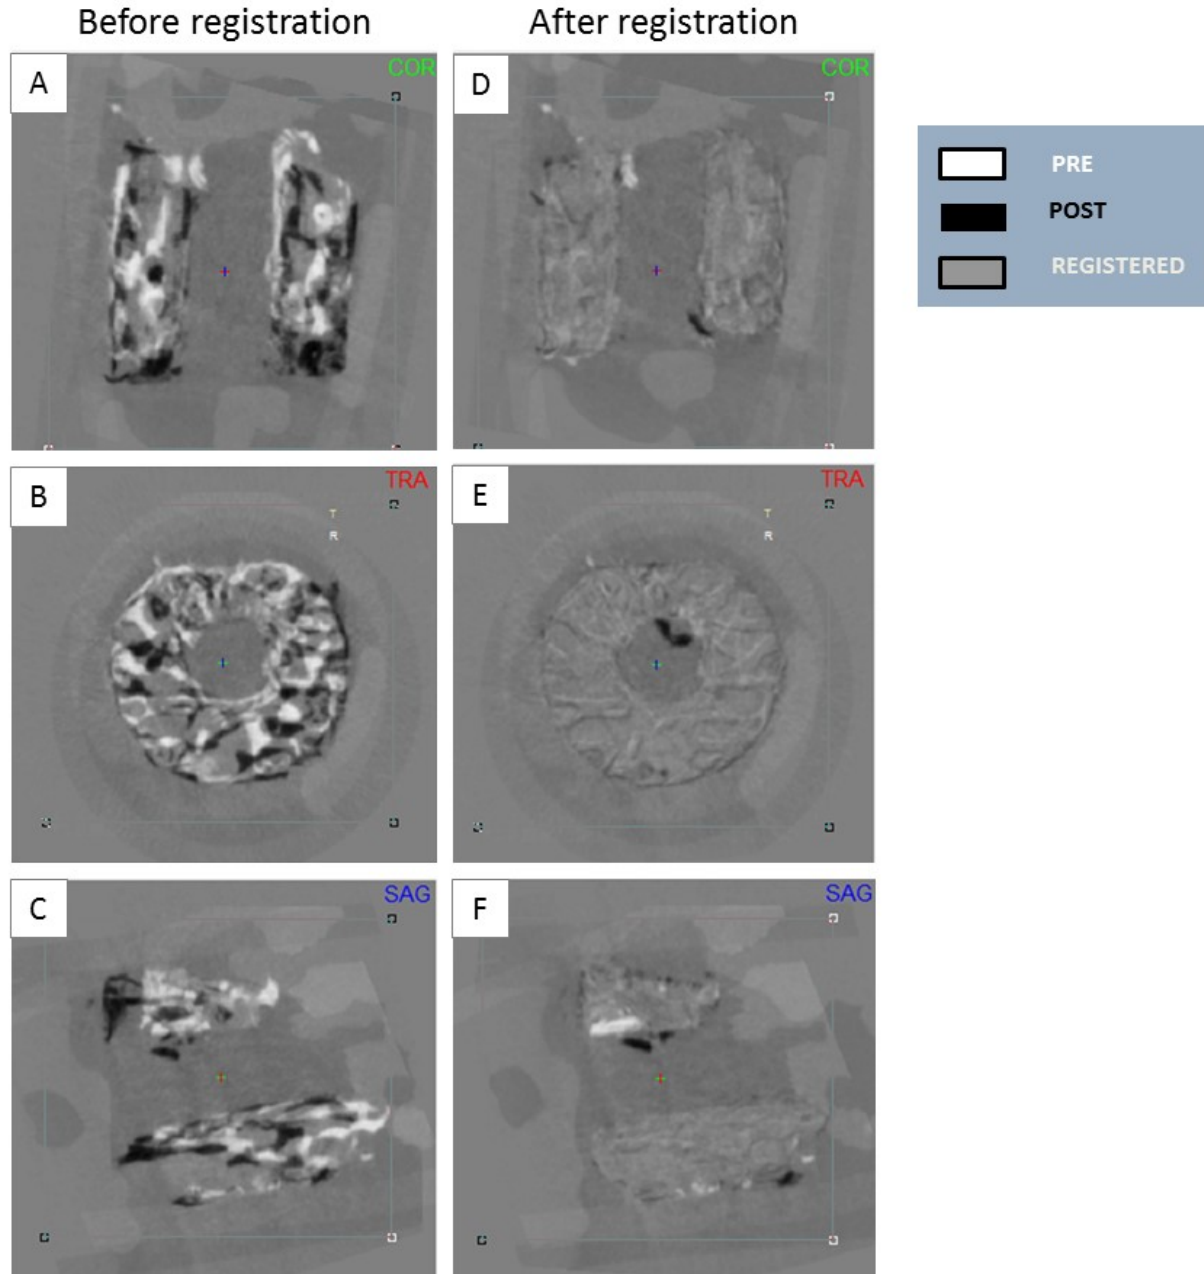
Three-dimensional registration of two sequential scans of the same human bone cylinder under the same X-ray settings and reconstruction parameters. Bone cylinder was scanned under the same X-ray settings with a week interval, obtaining day 0 scan (pre) and day 7 scan (post). (A-C) Before registration, DataViewer software loads pre and post dataset, however after inverting the greyscale of the post dataset (black). Following registration (D-F) successful superposition of pre and post dataset results in grey colour, while the unmatched structures remain in the colours displayed upon loading. Sagittal (SAG), transaxial (TRA) and coronal (COR) cross-sections.
